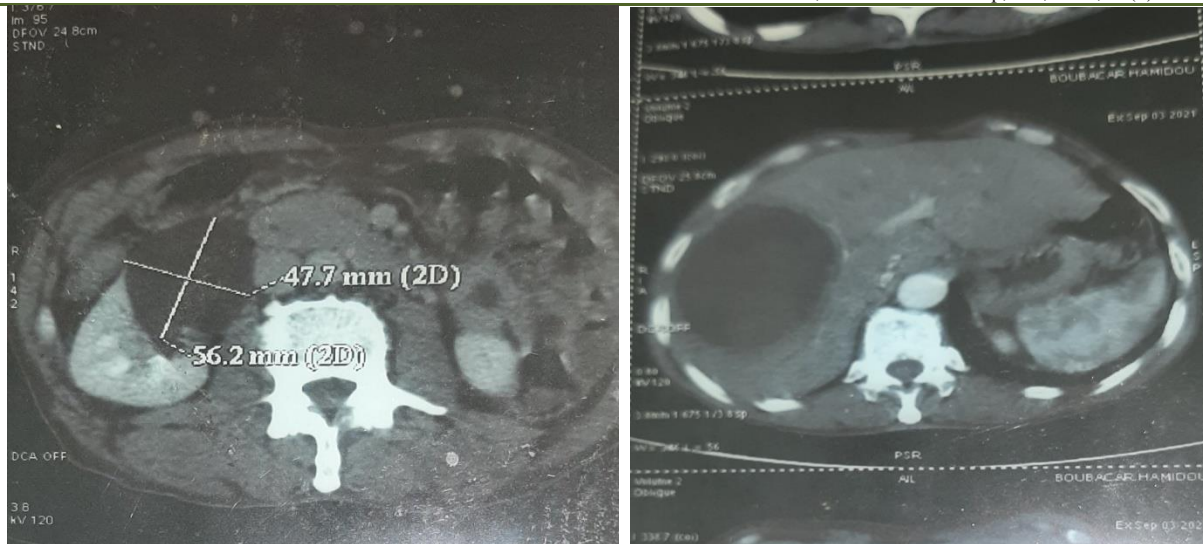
Hepatic CT showing voluminous right hepatic collection of 56.2 mm /47.7 mm
